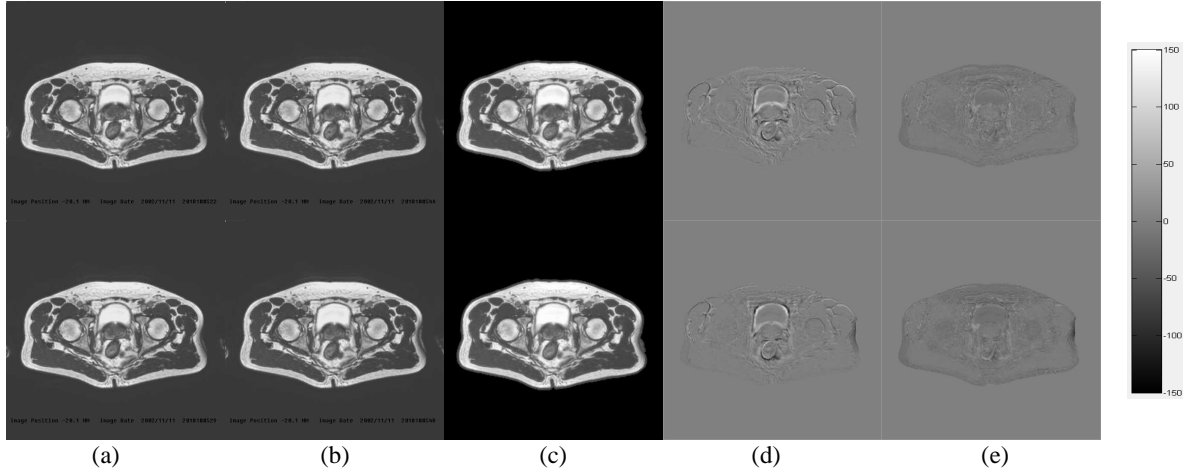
Validation results using real dynamic magnetic resonance image data
